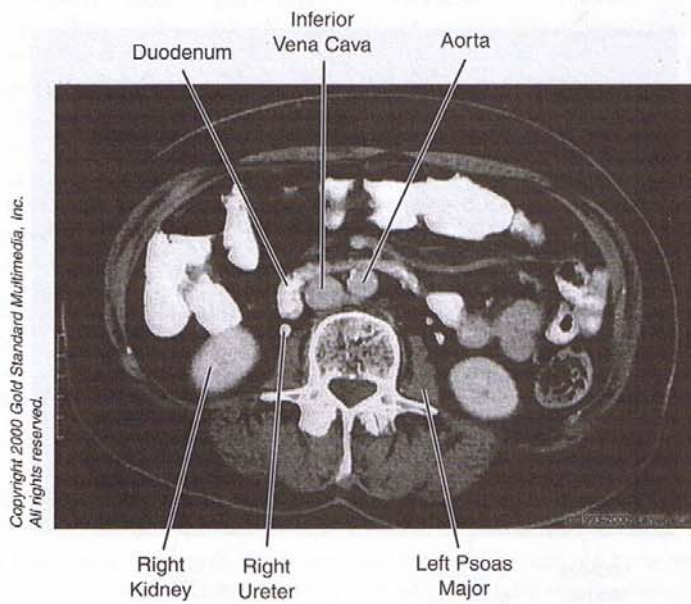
Abdomen: CT, L₃
